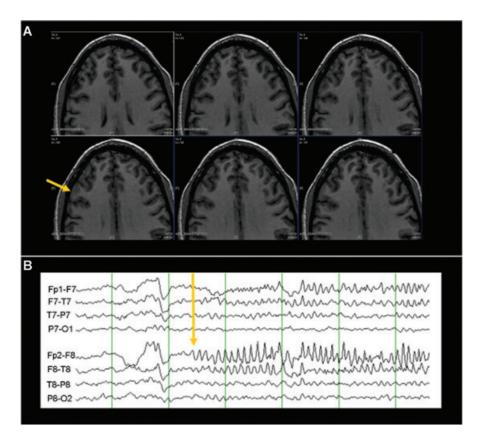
(A) A 3T MRI showing possible subtle right frontal lobe cortical dysplasia. (B) Electroencephalogram obtained at the time of the patient's first (ictal) FDG-PET study, showing a typical right frontal electrographic seizure (onset marked by arrow.) These seizures recurred every 5-30 seconds throughout the 1-hour scanning session.
